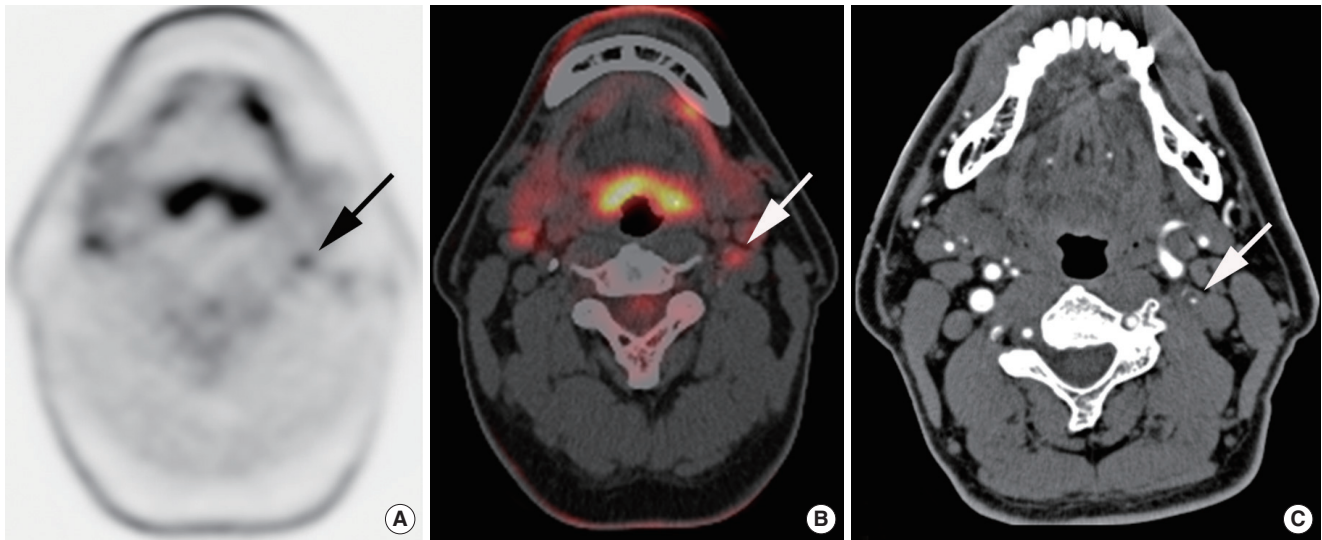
Positron emission tomography-computed tomography (PET-CT): arrow indicates (A) ^{18}F -FDG PET and (B) PET-CT showing a high uptake in left internal carotid artery, and (C) CT angiography showing severe stenosis of the left internal carotid artery with an atherosclerotic plaque.
